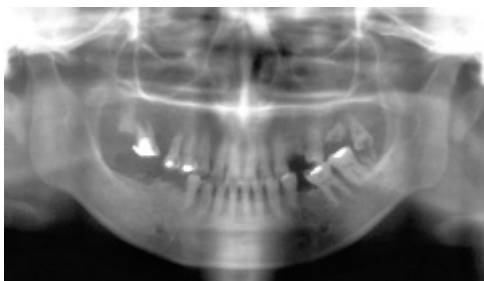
Radiograph taken at presentation (25 years of age). The dental pulp cavity is difficult to see in the anterior teeth, and is narrowed to a thread-like shape in the premolars. The dental pulp cavity is clearly visible in the molars.
